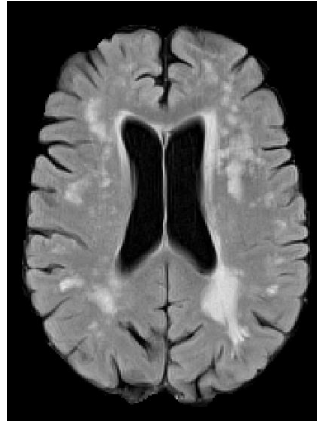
Wide WMH lesions clearly visible on a FLAIR image as white marks.
